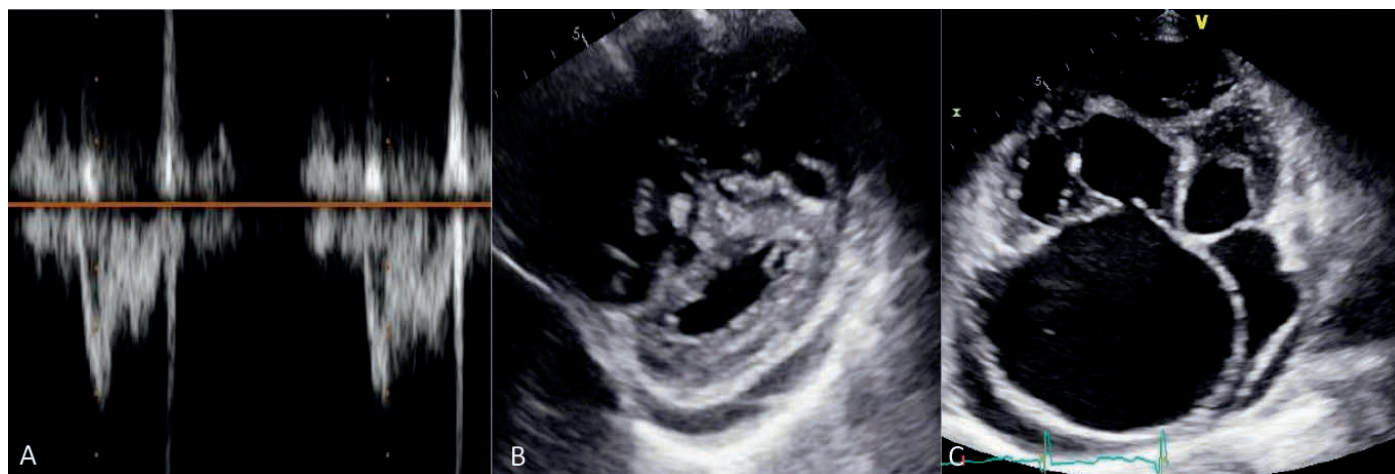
Echocardiography imaging: (A) Right ventricular (RV) outflow tract Doppler notch with reduced acceleration time. (B) Severe systolic septal flattening. (C) Severe right atrial and RV enlargement with RV hypertrophy and pericardial effusion.
